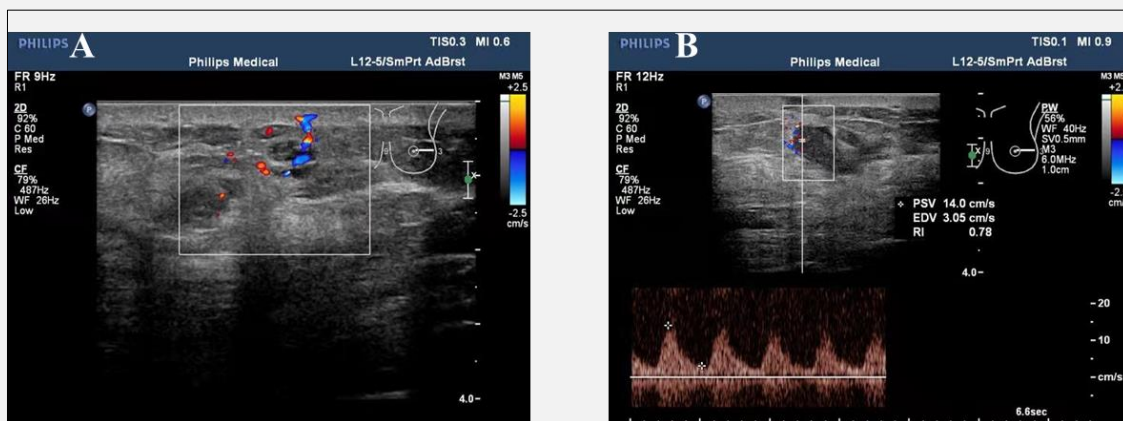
Two-dimensional ultrasound imaging of recurrent lesions in UPS of the breast.
